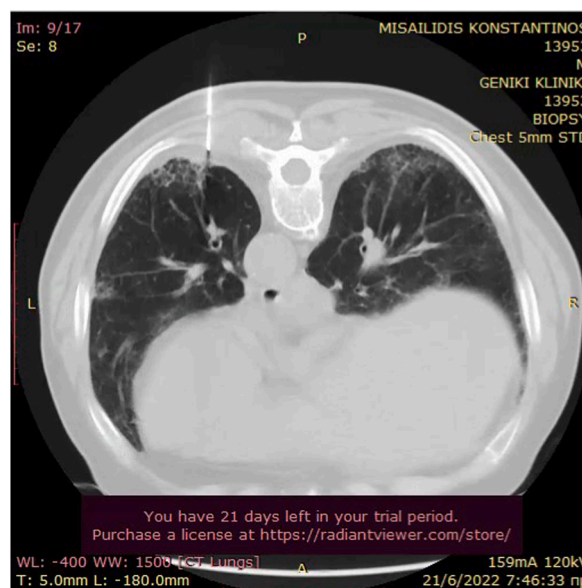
Biopsy with 18G needle under CT guidance of the region with positive 16SUV uptake.
